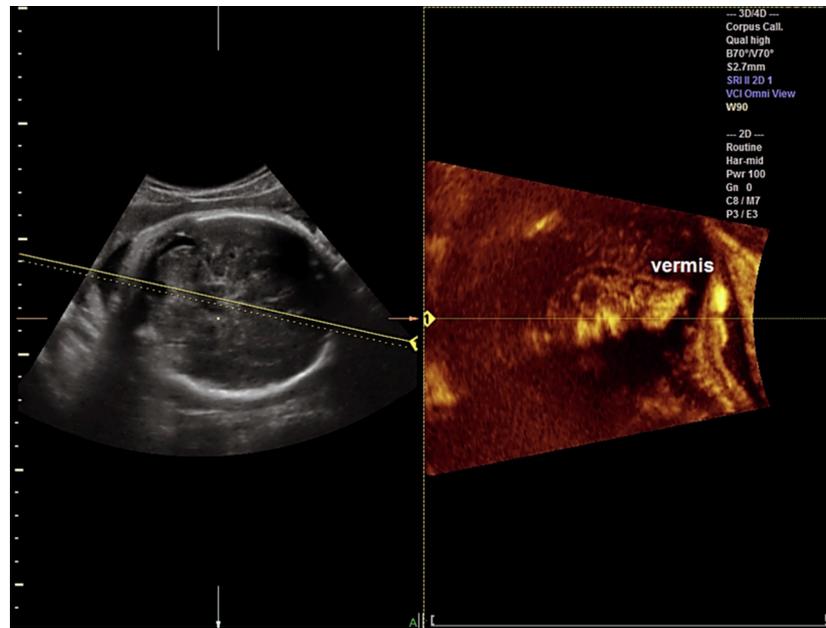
Fetal neurosonogram using Omniview with volume contrast image in the C-plane (VCI-C). Yellow line is drawn in oblique direction through the posterior fossa enabling reconstruction of the cerebellar vermis in a normal fetus at second-trimester scan.
